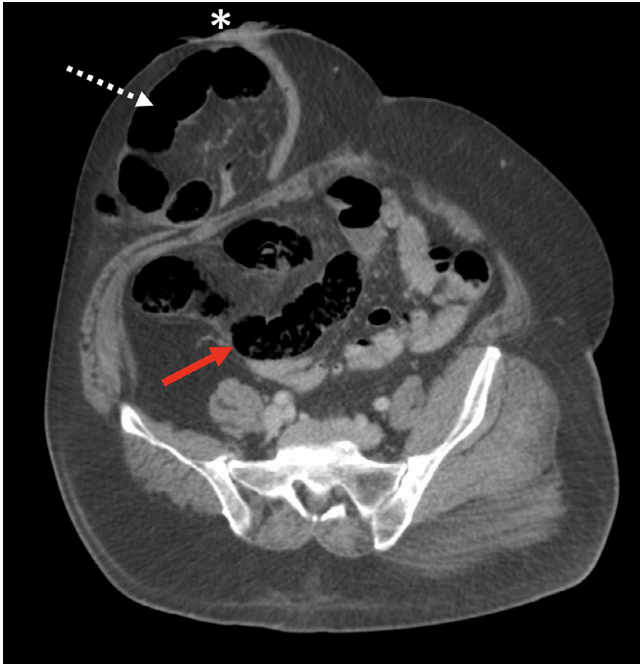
Incarcerated parastomal hernia. Transaxial CT scan demonstrates incarcerated ischemic parastomal hernial loops (dashed white arrow) adjacent to the ostomy (*). Dilated loops of small bowel (solid red arrow) are also seen in the central abdomen.
